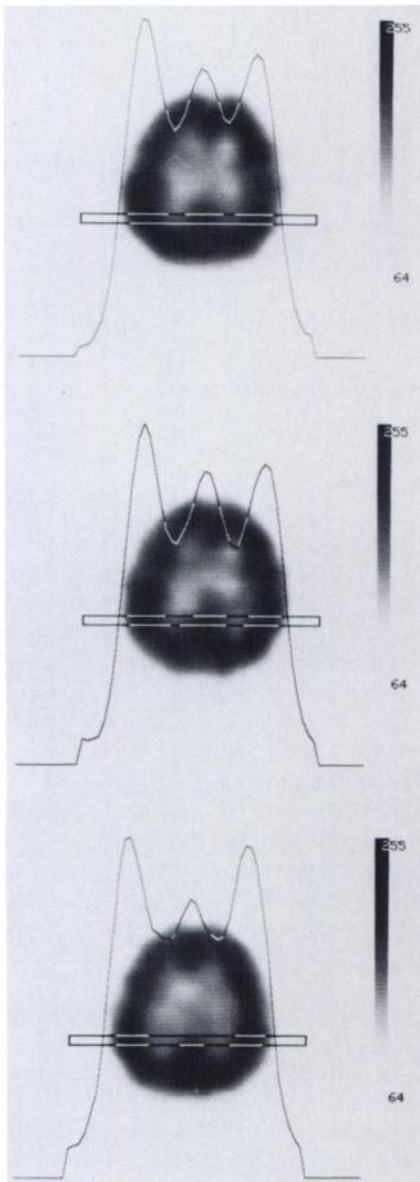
Horizontal ROI profiles through the area of abnormality in the three slices from Figure 3. Top and middle: right parieto-occipital hyperperfusion, corresponding to the first and second HMPAO-SPECT studies. Bottom: symmetric perfusion in both parieto-occipital regions, corresponding to the third study (see text).
